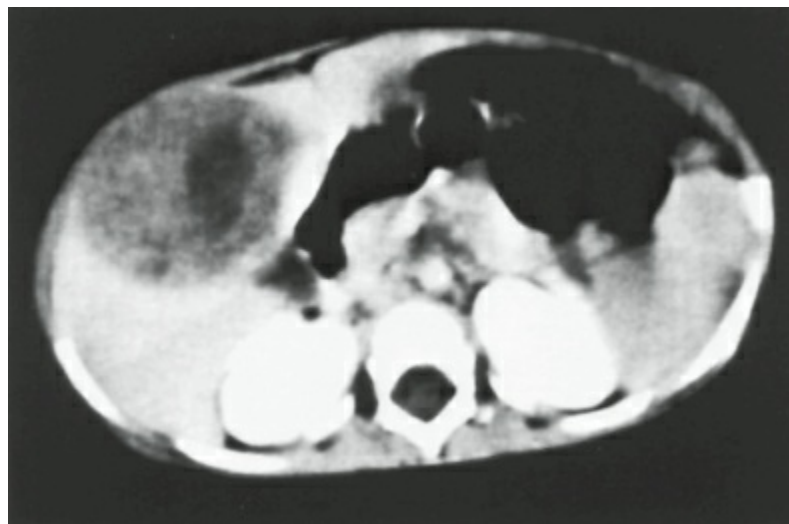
Computed tomographic scan of the abdomen demonstrating an infant with hepatoblastoma of the right hepatic lobe.
